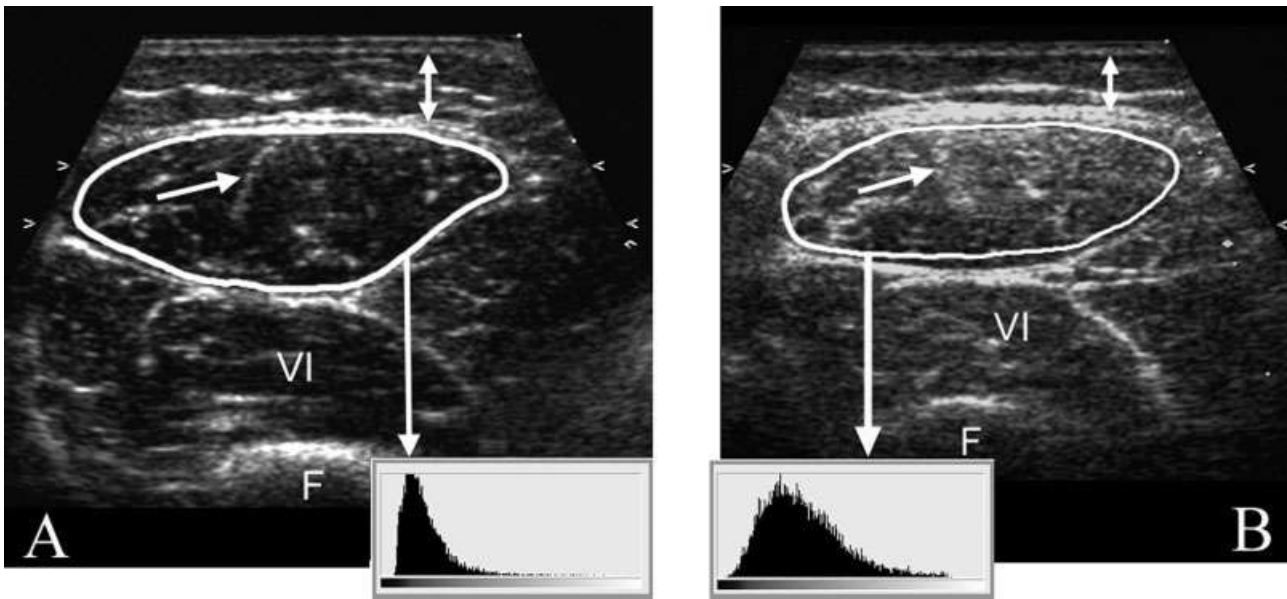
Transverse ultrasound image of a normal left quadriceps muscle (A) and of a patient with Duchenne muscular dystrophy (DMD) (B). Both are 3.5 years of age. The rectus femoris muscle is encircled. The mean echo intensity is measured for this region, as shown in the histograms below (scale: black = 0; white = 255). The rectus femoris of the DMD patient has increased muscle echo intensity, with the corresponding histogram being displaced to the right. Note the fine granular pattern of echo intensity, homogeneously spread among the muscle with attenuation of the ultrasound beam; that is, the echo intensity in deeper areas of the muscle is decreased compared to the superficial areas. Fascia within the muscle, such as the central fascia in the anterior part of the rectus femoris (single arrow), are more difficult to recognize in the DMD patient. VM, vastus medialis; VL, vastus lateralis; VI, vastus intermedius; F, femur; double arrow, subcutaneous tissue. The quadriceps muscle was measured halfway along the line from the anterosuperior iliac spine to the patella.
